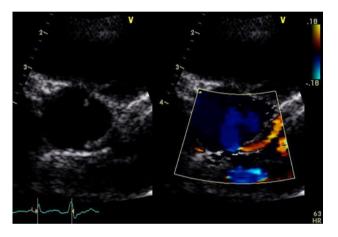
Case 1. Preoperative echocardiogram showing the origin of the left coronary artery from the noncoronary sinus of Valsalva in two dimensions and with color Doppler
